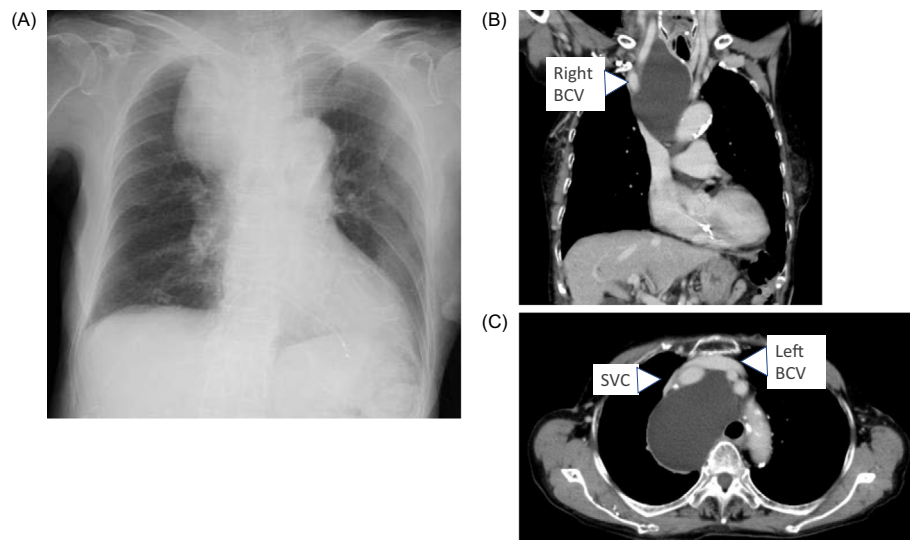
Diagnostic imaging of the mediastinal tumor. (A) Chest X-ray, (B) coronal view (contrast computed tomography), and (C) axial view (contrast computed tomography). BCV: brachiocephalic vein, SVC: superior vena cava
